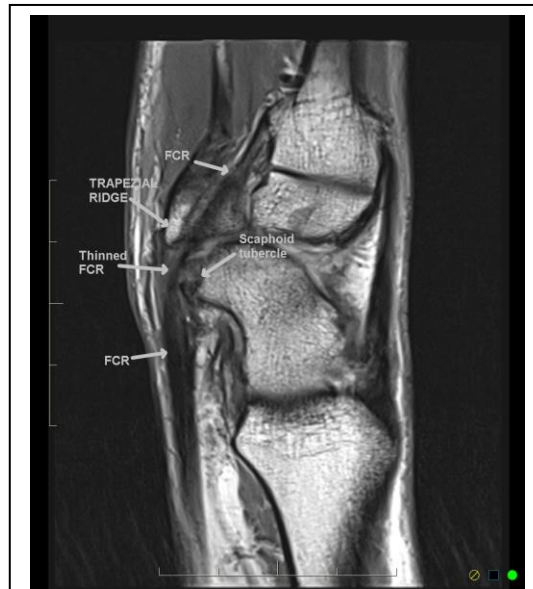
MRI (Proton Dense Sagittal) scaphoid spur with tendinopathy and tear of FCR in the segment arching over the scaphoid tubercle (Spur) diving under an irregular trapezial ridge, prior to insertion at the 2nd metacarpal base.
